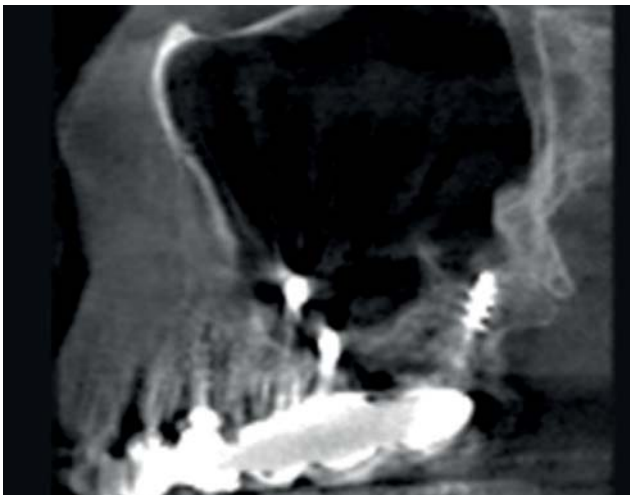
and 7 Radiographic sections of the scanner showing the most distal implants, one with anchorage in the cortical of the sinus floor and the other in the cortical of the pterygoid.
